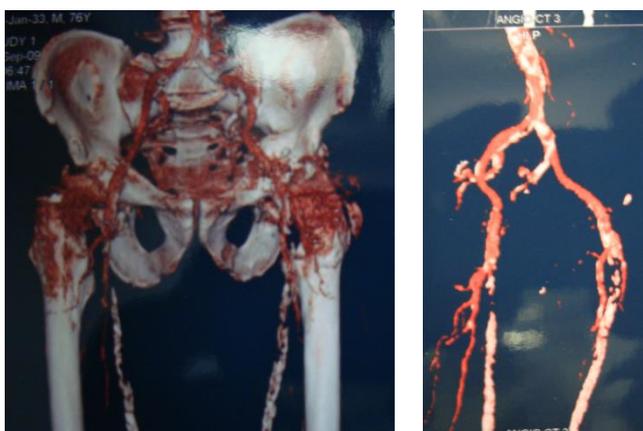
CT angiogram showing a conflict between the migrated acetabular cup and the iliac vessels of the left hip.
